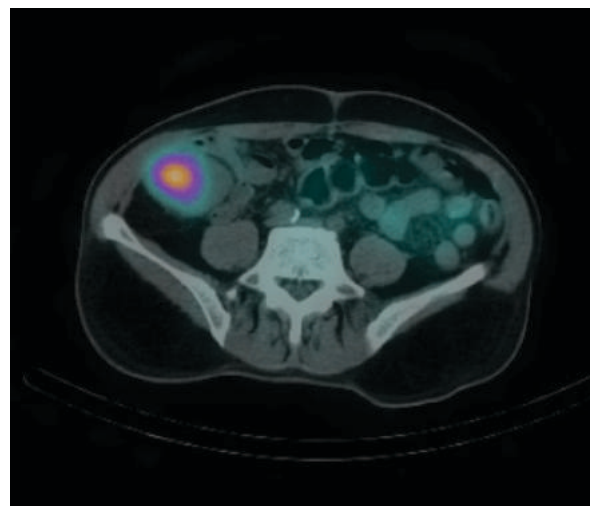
Gallium CT demonstrating pyelonephritis in a transplant kidney.
